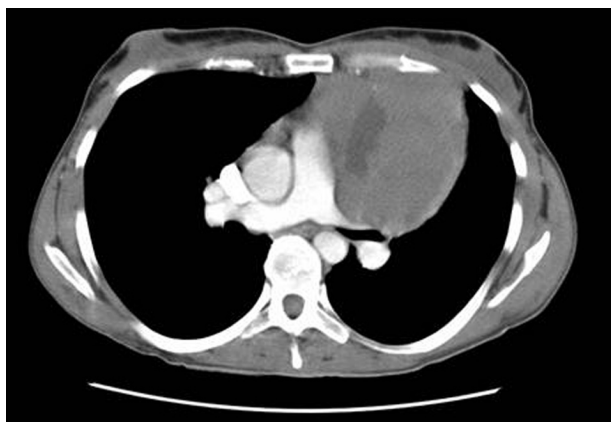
The tumor in the upper mediastinum in the CT-scan (external compression of the central airways mainly the left bronchus).
